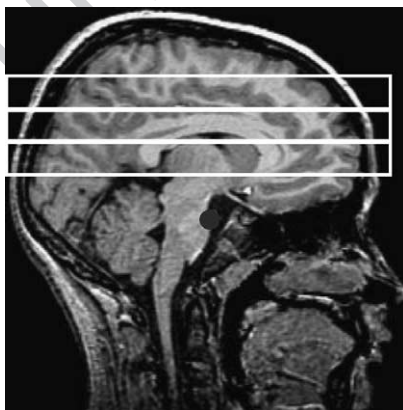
Sagittal T1-weighted MRI of brain of a 9.6-year-old schizophrenic girl showing positioning of three ^1H MRSI acquisition slices.
